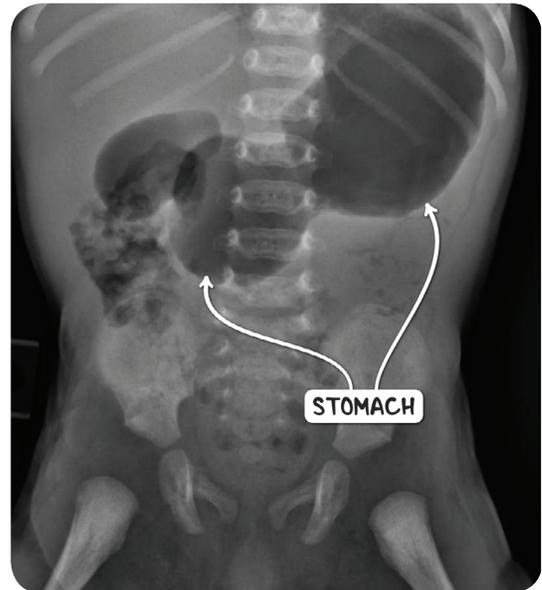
An abdominal radiograph demonstrating a grossly dilated stomach, secondary to obstructive pyloric stenosis.
